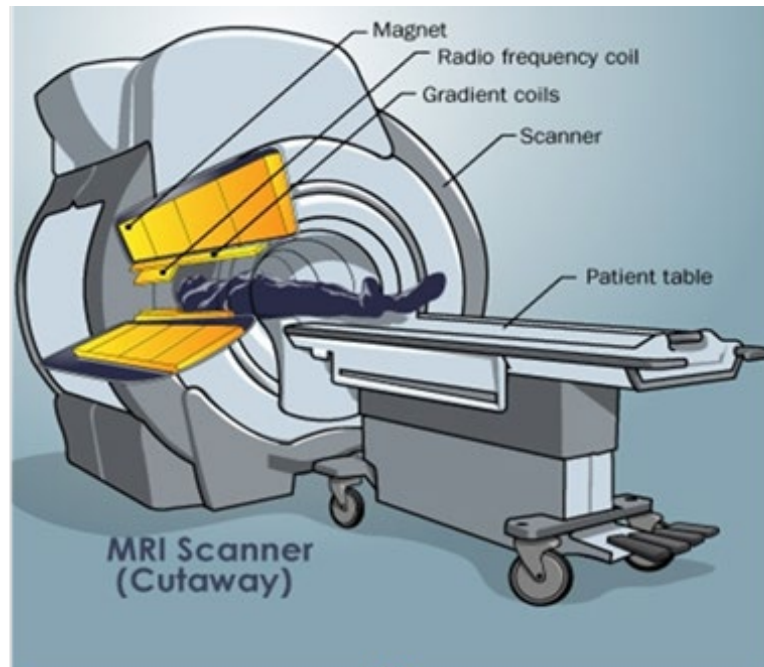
MRI scanner cutaway showing main components [2].
